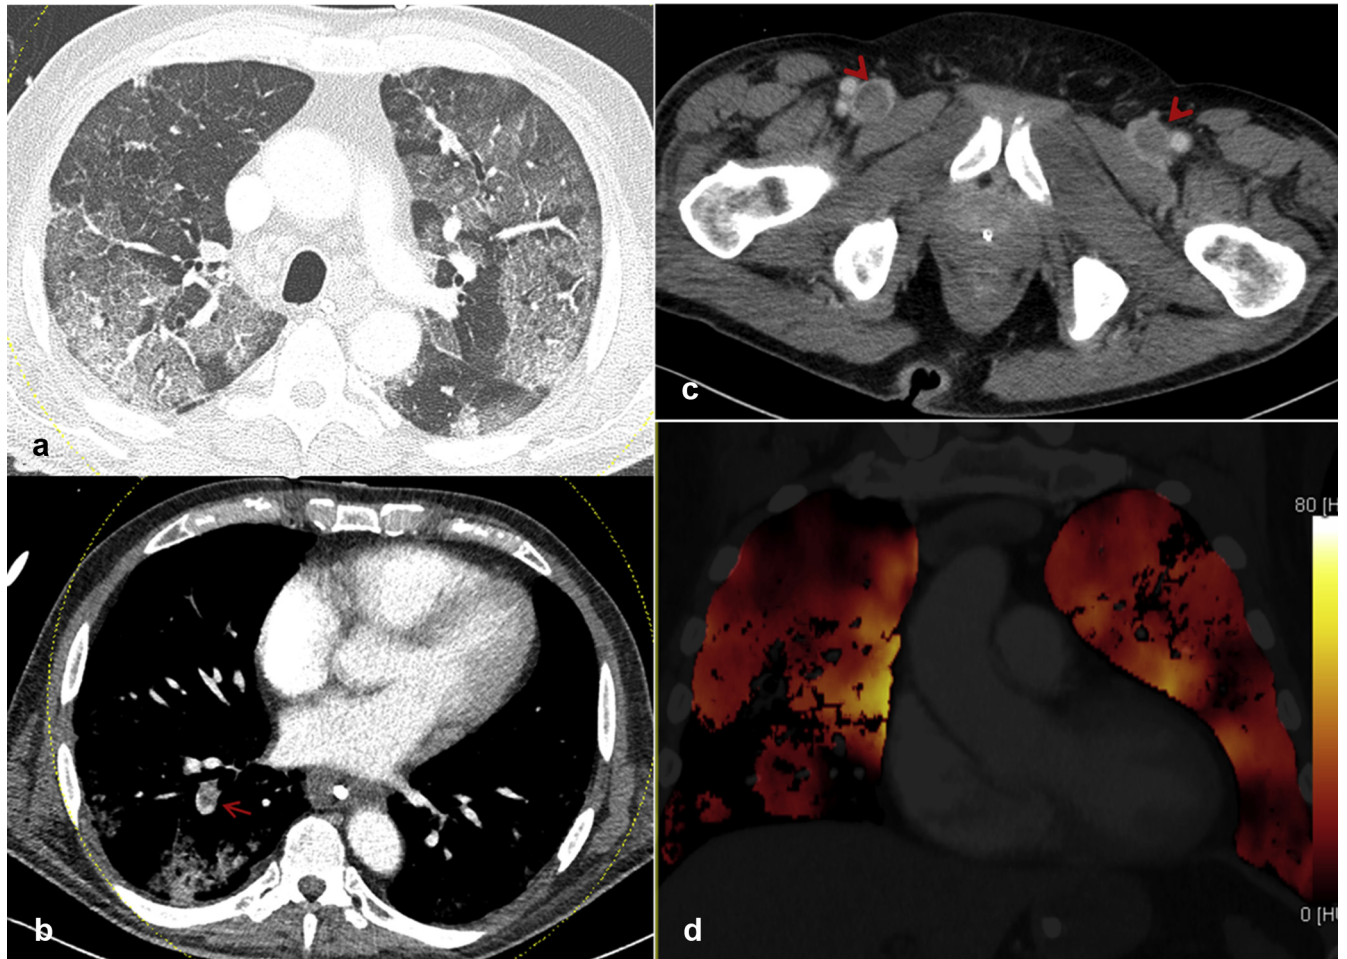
Axial reconstructions of contrast-enhanced CT with dual-energy technique demonstrate extensive pulmonary opacities in advanced COVID-19 pneumonia (a). Furthermore, pulmonary embolism (b, arrow) and bilateral deep vein thrombosis (c, arrowheads) are present. (d) The coronal iodine map derived from the dual-energy data set demonstrates multiple peripheral wedge-shaped perfusion defects.
